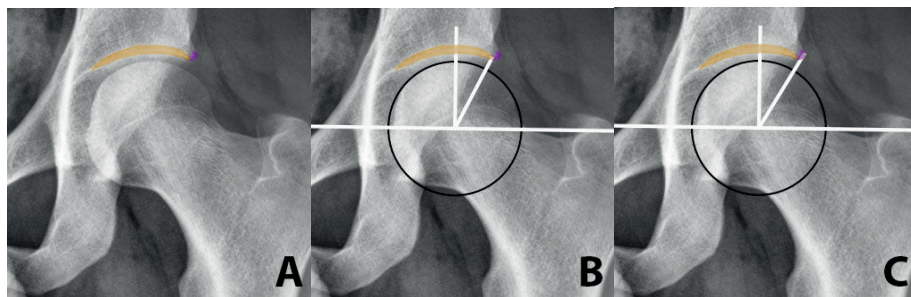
The Wiberg center edge angle (WCEA) and the lateral center edge angle (LCEA) as measured on an anteroposterior pelvic radiograph of the same person. The pelvic radiograph is cropped to the left hip. A: The acetabular sourcil, the weight-bearing part of the acetabulum, is indicated in orange. The additional bony coverage is indicated in purple. B: The WCEA determined using the most lateral point of the sourcil. C: The LCEA determined using the most lateral bony point of the acetabulum.
